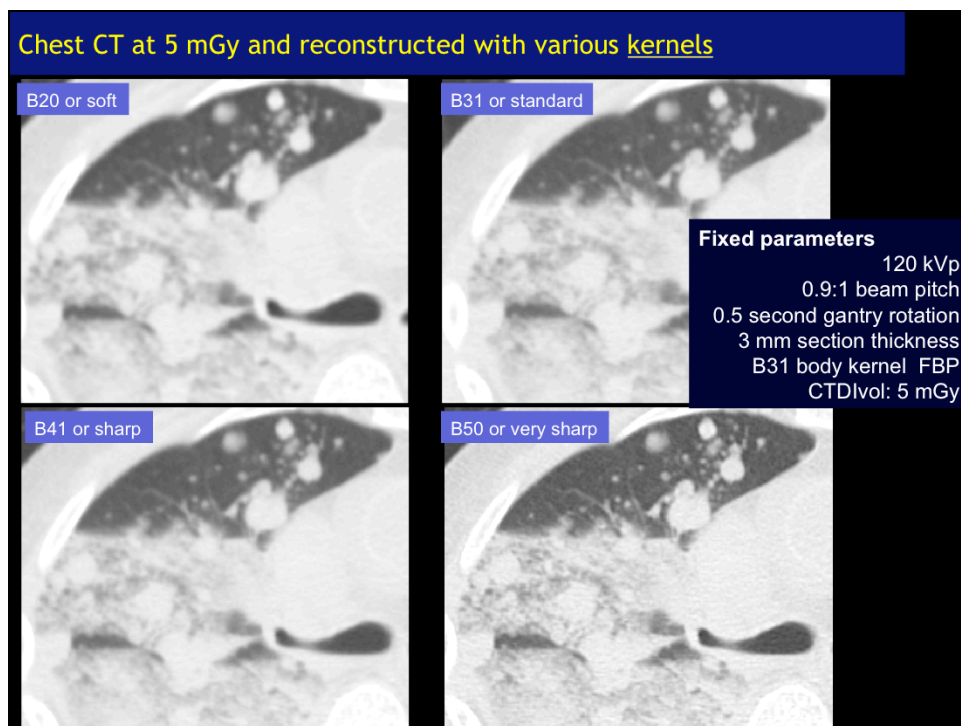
Transverse chest CT images acquired at 75 mAs (CTDIvol 5 mGy) and reconstructed with v
